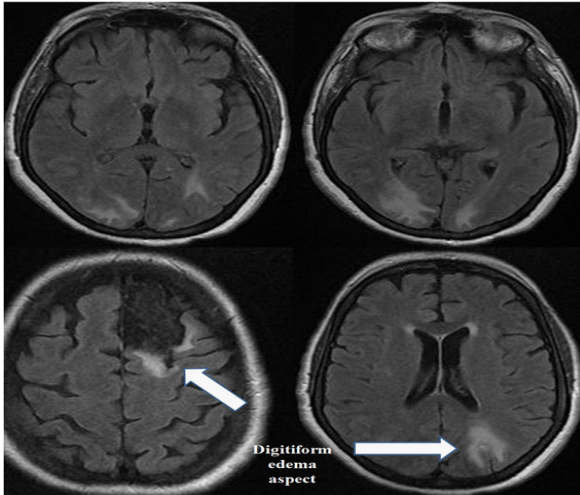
Findings on acute CT showed subcortical areas with greater density than the cerebrospinal fluid, with a digitiform edema aspect, more evident in both the occipital and left parietal lobes. Reduction of groove and fissure amplitude, mainly in high convexity and cerebellum. Besides, presenting a hypodense area in the left frontal lobe, a density close to that of the cerebrospinal fluid compatible with previous ischemia.
